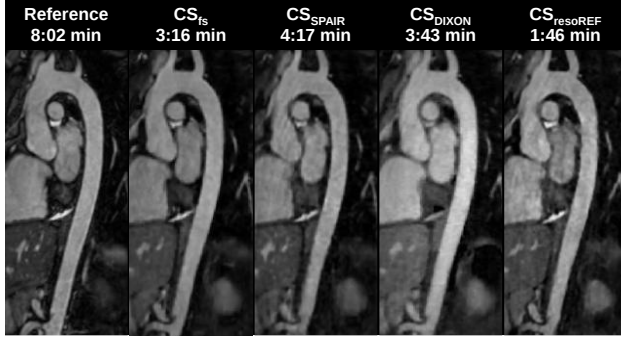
Examples of mid-thoracic aortic slice along with scan time obtained using each 3D aortic MRI angiography sequence in a 27-year-old healthy man.
